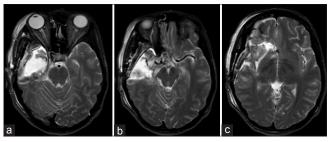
Immediate postoperative axial T2WI MRI revealing right temporal lobectomy, amygdalo-hippocampectomy and right frontal lobe disconnection with no evidence of complications
